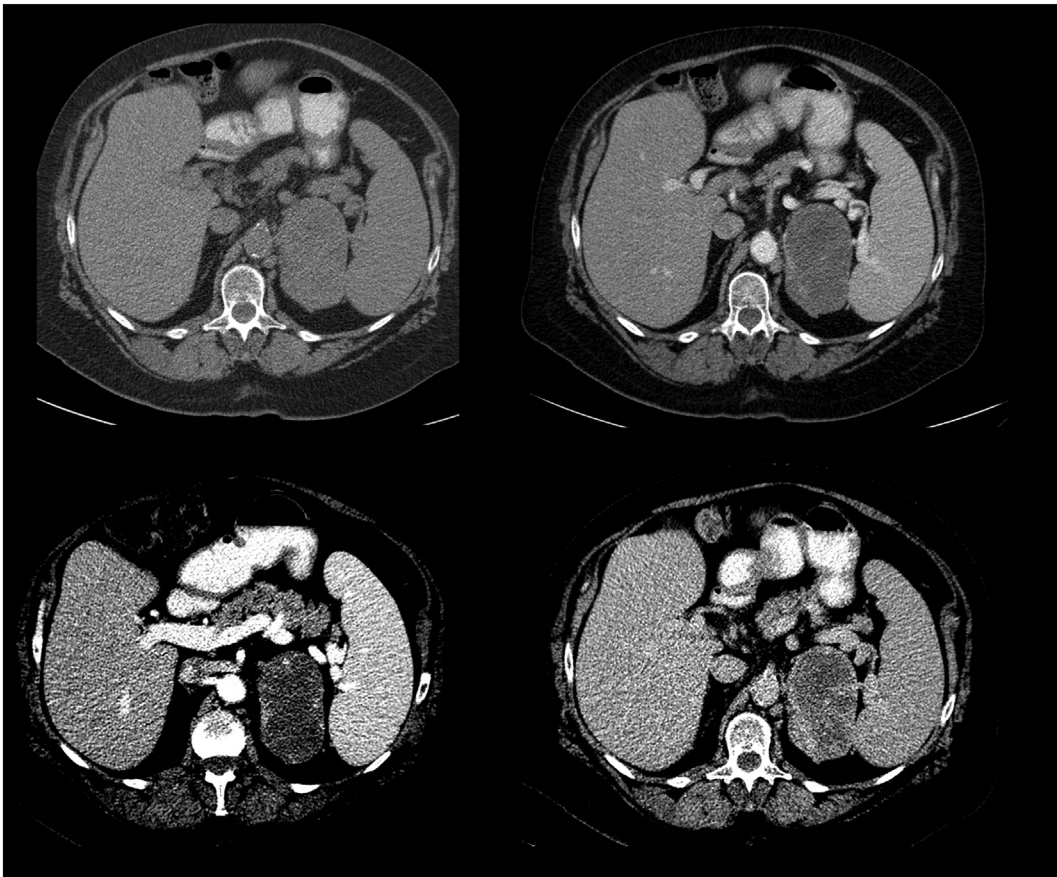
CT imaging of left adrenal mass using an adrenal protocol demonstrating a solid left adrenal mass measuring 10 cm × 9 cm × 6 cm, with an attenuation value of 29 HU on the noncontrast view (A). Peripheral nodular discontinuous enhancement is seen on the portal venous phase (B) and on the narrow window view (C). Delayed imaging demonstrated contrast filling the mass from the periphery (D).
